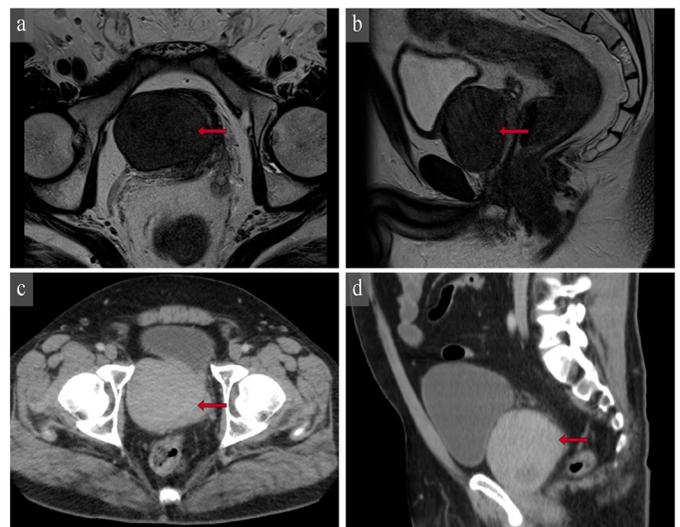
(a) Axial T2WI, (b) Sagittal T2WI. On dynamic gadolinium-enhanced magnetic resonance imaging (MRI) of the abdomen, a 48×66 mm well-circumscribed mass and homogeneous enhancement was observed at the right anterolateral side of the prostate. (c) Axial CT, (d) Sagittal CT images at three years of follow-up. CT scan showed that the size of the mass was increased and measured as 77×82 mm. The arrows indicate the mass
